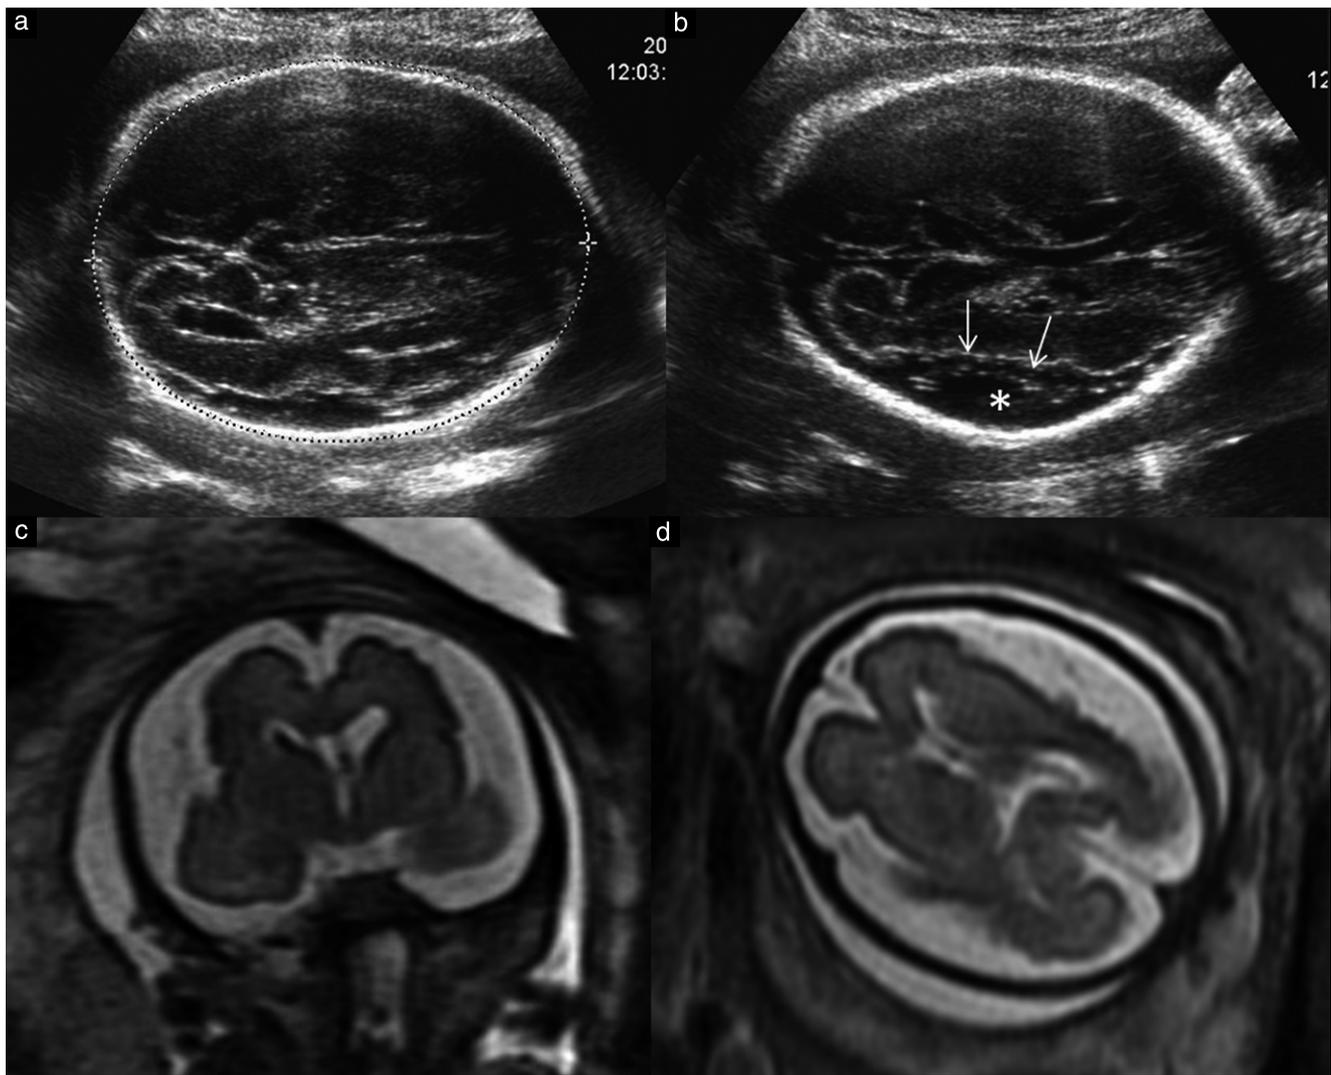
Fetal imaging in a patient referred at 27 gestational weeks due to unexplained enlargement of pericerebral space. Cephalic biometry was close to 50th percentile (head circumference, 270 mm). Axial sonographic images (a,b) confirming enlargement of the pericerebral space, which was more pronounced close to the corona radiata (*), associated with abnormal smooth cortical surface (arrows). Coronal (c) and axial (d) T2-weighted fetal magnetic resonance images (MRI) demonstrating both a major diffuse increase in pericerebral space and diffuse anomalies of the cortical ribbon, which show lack of gyration and an undulated cortical surface suggestive of diffuse polymicrogyria. Cephalic biometry at MRI gave biparietal and fronto-occipital diameters of -3 SD and -5 SD, respectively, according to the atlas of Garel³³. Pathological examination confirmed both microcephaly, as suggested by a cerebral weight of 140 g ($< 5^{\text{th}}$ percentile), and diffuse polymicrogyria, associated with neuronal and leptomeningeal cortical heterotopia, suggestive of a diffuse clastic mechanism (not shown).
